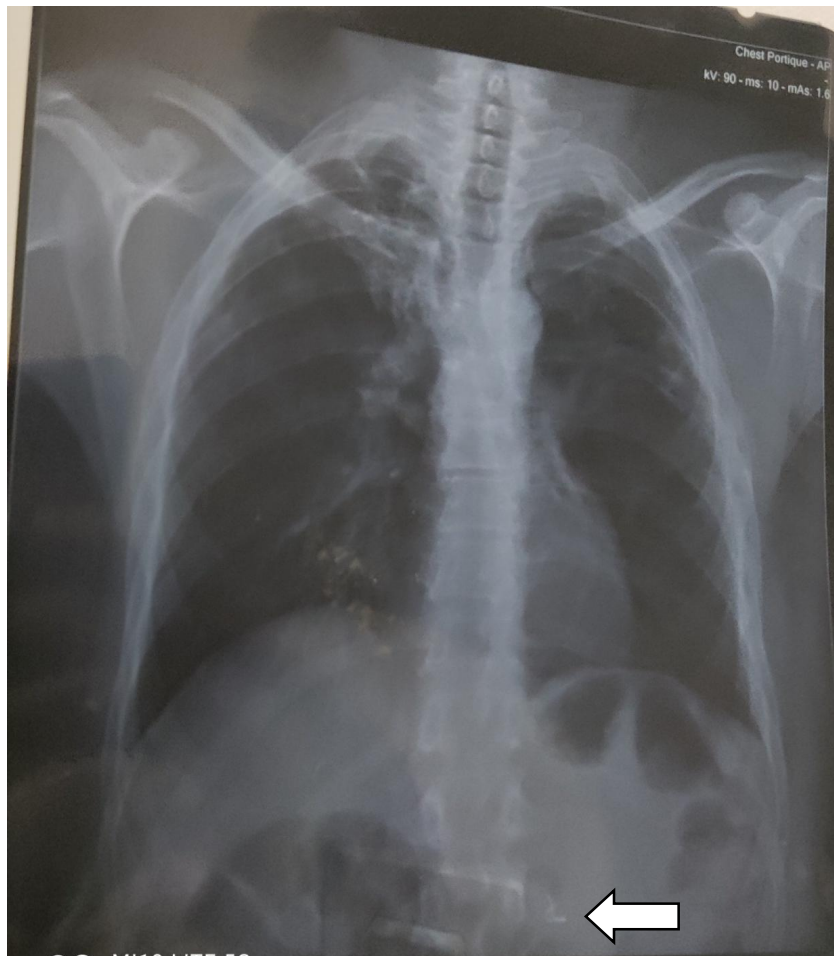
Chest X-ray: visualization of radiopaque foreign body
